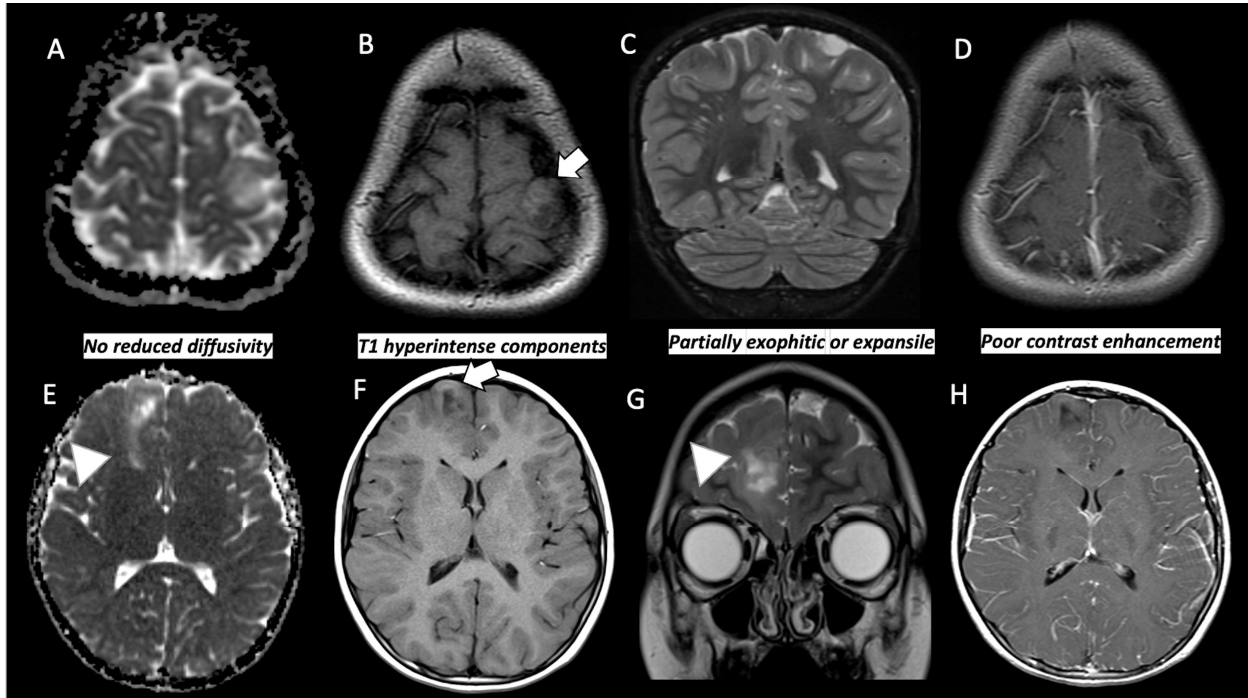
Angiocentric glioma, *MYB-QKI* fusion positive in two different patients. Axial ADC map and T1-weighted as well as coronal T2-weighted, and axial T1-weighted post contrast images of the brain in two different patients show a cortical based lesion with internal T1-hyperintense components (similar to the adjacent white matter) (white arrow) and a stalk-like sign (arrowhead).
